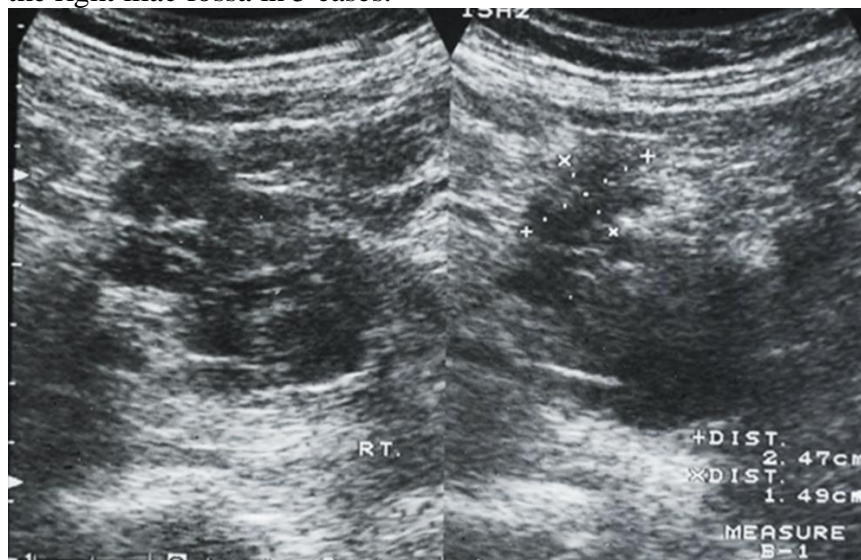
Sonogram (long & trans) showing multiple hypoechoic lymph nodes
